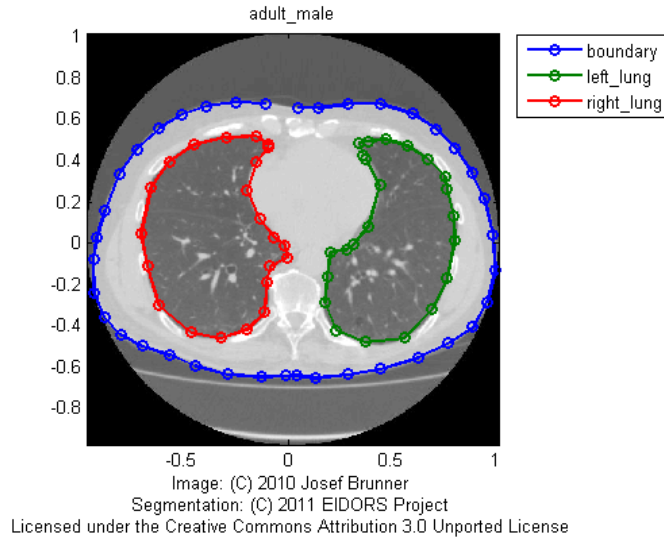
A lung healthy 49 year old adult male of average build CT slice and boundaries.
